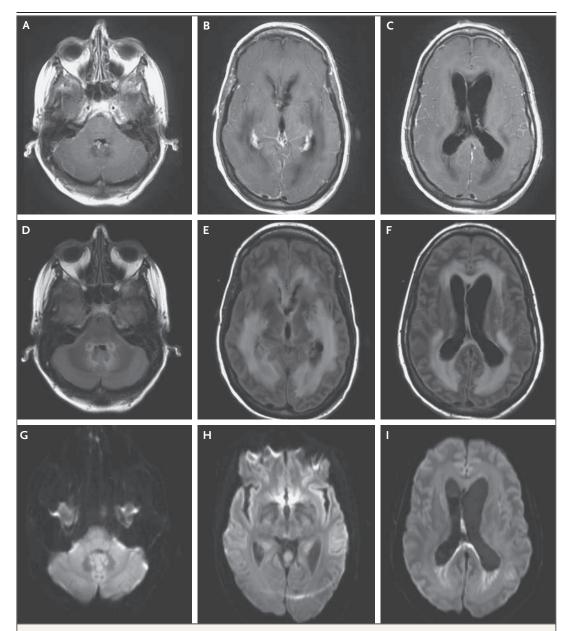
Additional MRI of the Head.
